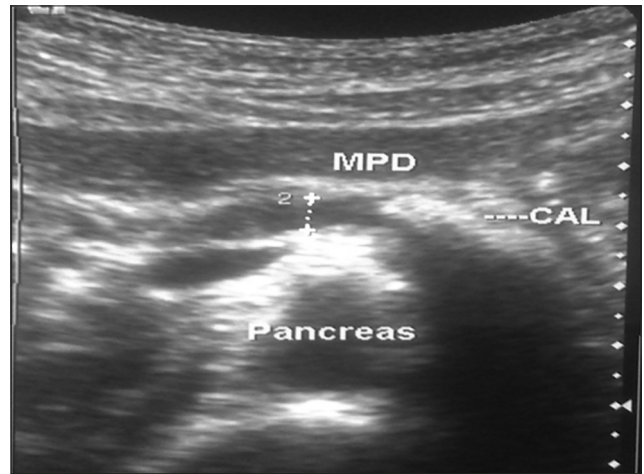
Ultrasound showing features of chronic calcific pancreatitis (Main Pancreatic Duct MPD dilatation, intraductal calculus)
